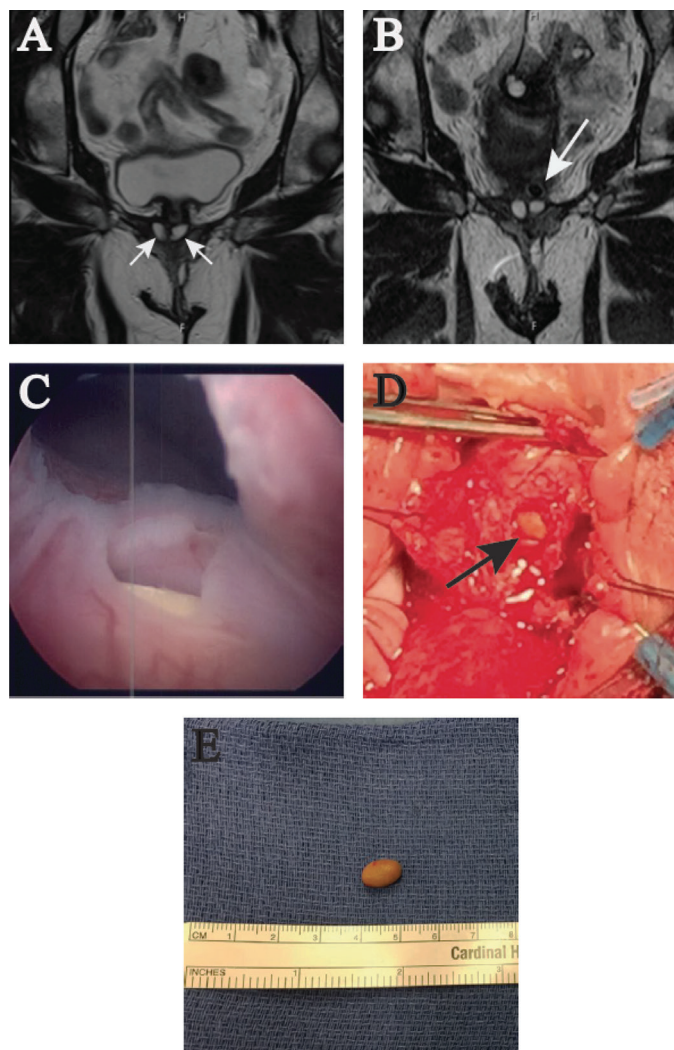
A) T2 weighted magnetic resonance imaging showing bilobed diverticulum (arrows), B) T2 weighted magnetic resonance imaging showing a calculus within the left lobe of the diverticulum (arrow), C) cystoscopy revealing ostium of diverticulum containing a calculus in close proximity to the bladder neck, D) vertical incision and entry into diverticulum sac, E) calculus excised from left lobe of diverticulum
